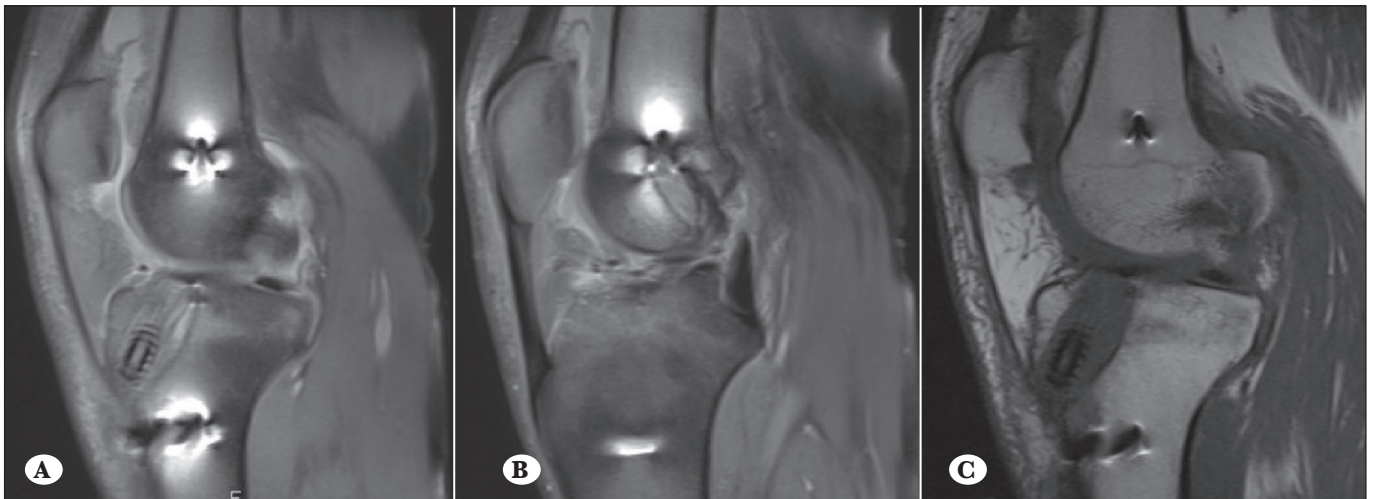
(A, B) Sagittal PD-weighted fat suppressed MR images showing anterior placement of the tibial tunnel in relation to the projected slope of the intercondylar notch resulting in marked ACL graft impingement against the anterior inferior margin of the intercondylar roof. (C) Sagittal T1 MR image for the same patient demonstrating the significantly widened tibial tunnel.
